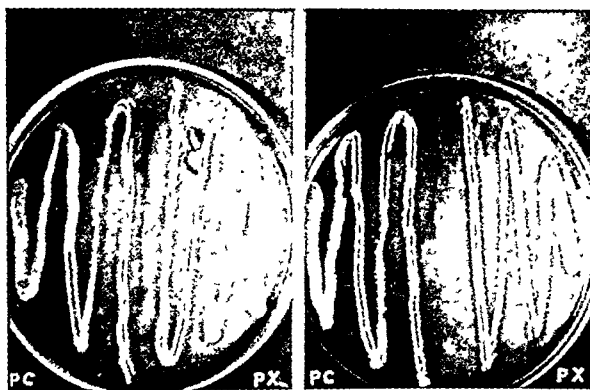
(fourth plate). Miscellaneous. PC, Staphylococci suspended in normal salt solution after standing for one hour—control. PX, Same suspension as above, placed in a small well 1 cm. beneath the surface of paraffin and treated by x-rays for one hour. The same x-ray factors were used as for meat.
